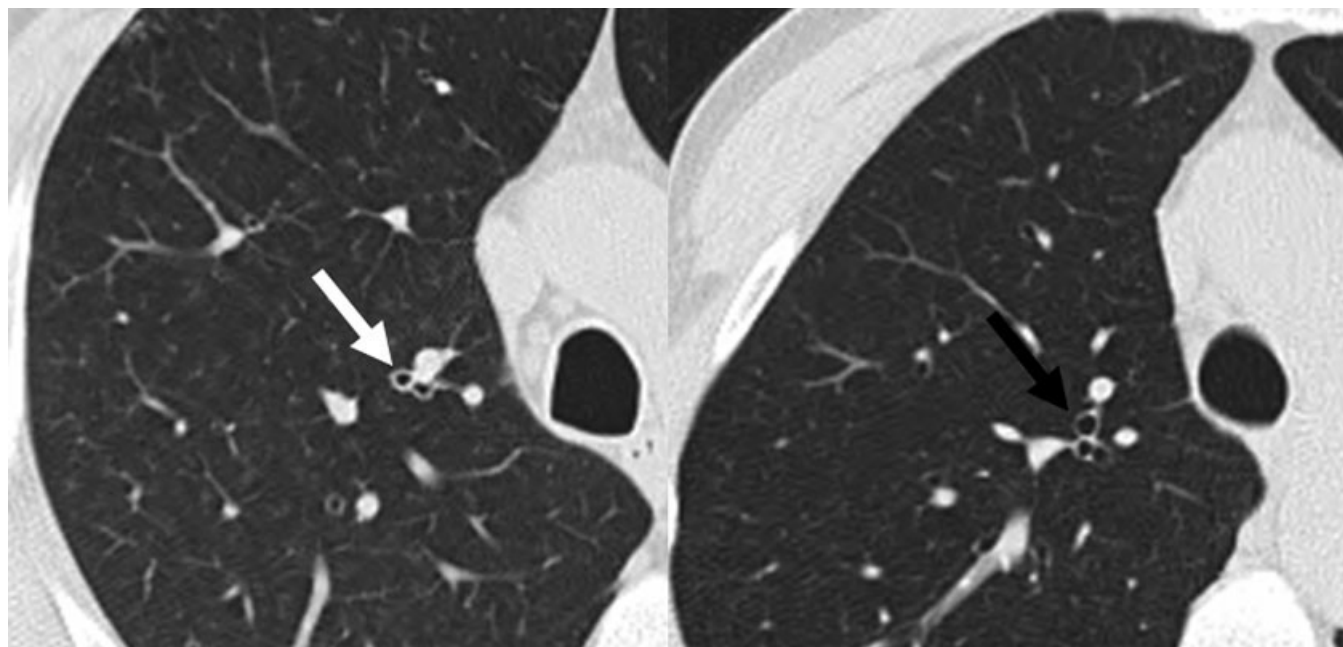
High-resolution computed tomographic images demonstrating bronchial wall thickening. Images were obtained from similar lung anatomic levels in a subject positive for anti-cyclic citrullinated peptide antibodies and rheumatoid factor isotypes IgM and IgA (left), and from an autoantibody-negative control (right), who were matched for age, sex, and smoking status. The image on the left shows bronchial wall thickening (white arrow). In contrast, the image on the right shows a normal-appearing thin-walled bronchus (black arrow).
